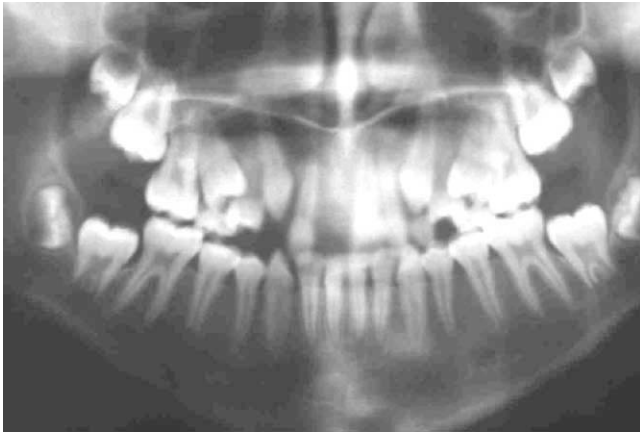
Panoramic radiograph reveals avulsion of primary tooth “c” and central incisor.
